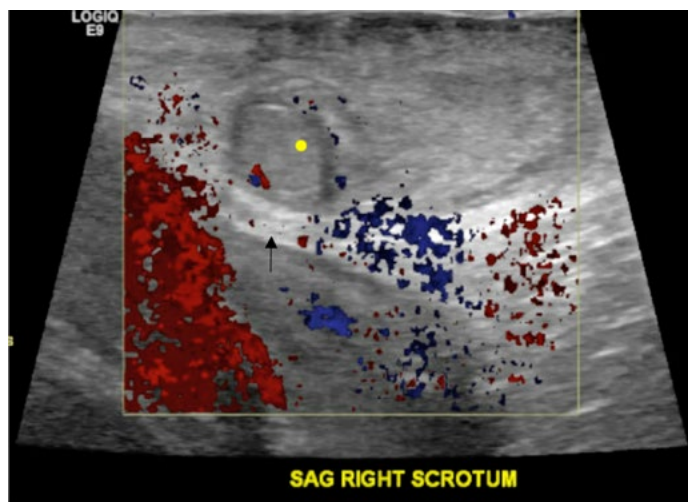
Scrotal ultrasound of right testicle with color doppler (yellow dot is right testicle and black arrow showed marked soft tissue and subcutaneous thickening)
